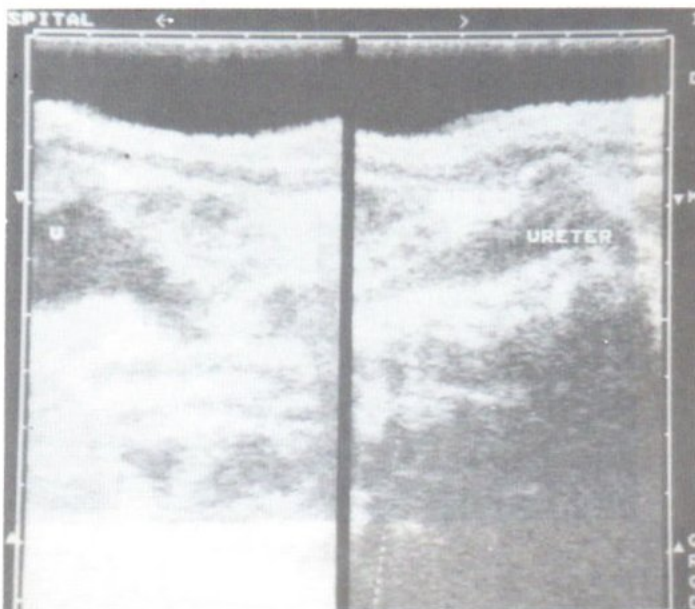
Ultrasound 1 day after delivery showed hydronephrosis of right upper system and tortuous dilated ureter, inability to demonstrate the entire ureter due to obscuring by the fetal bowel gas. U = upper system of right kidney L = lower system of right kidney.
